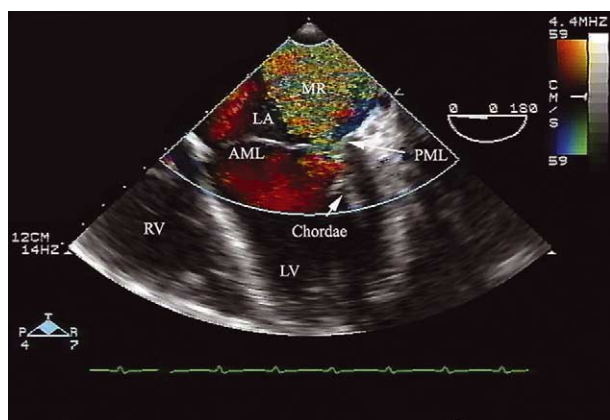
Transesophageal echocardiogram demonstrating severe mitral regurgitation (MR) associated with a posteriorly based jet and tethering of posterior mitral valve leaflet (PML) and subtending chordae to the posterior annulus (LA, left atrium; AML, anterior mitral valve leaflet; LV, left ventricle; RV, right ventricle).
